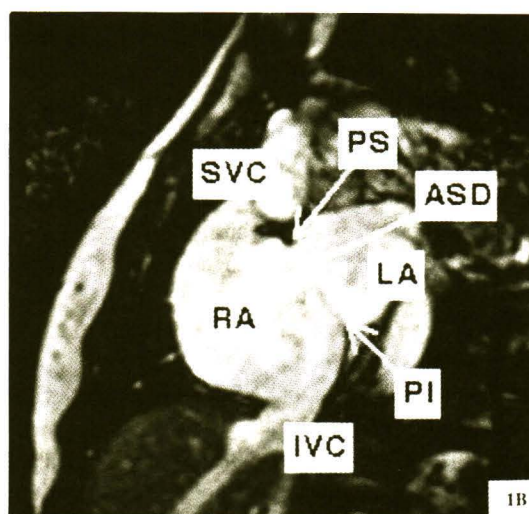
Cardiac MRI of an ASD showing a modified short axis view and sagittal view of the atrial septum with the right atrium to the left of the picture.
